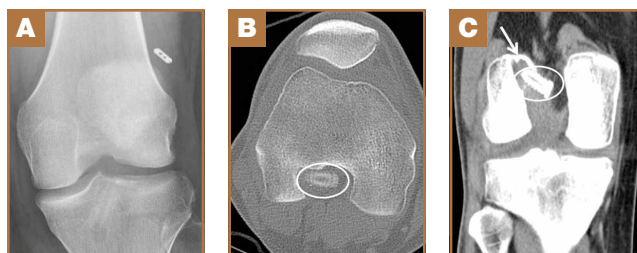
(A) Frontal radiograph shows cortical suspension fixation displaced from lateral femoral cortex. (B) Axial and (C) coronal computed tomography shows dislodged interference screw (circles) and tunnel widening (arrow), reflective of loosening.
